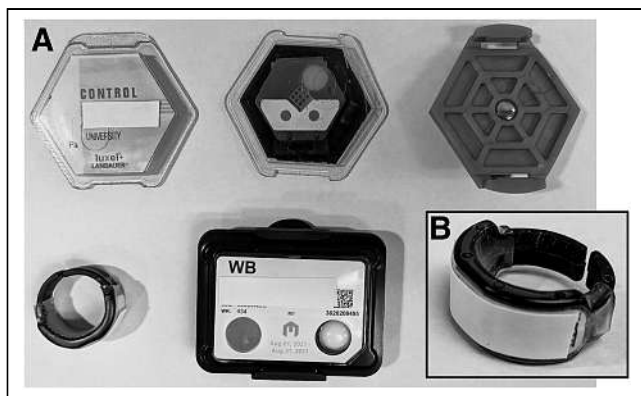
Radiation monitoring badges measure over time and do not provide real-time radiation exposure read-out. (A) Clockwise from top left: Luxel+ (Landauer) dosimeter badge that measures radiation exposure due to x-rays, γ -rays, and β -rays with optically stimulated luminescence (OSL) technology (15); inside of OSL badge; holder clip for Luxel+ OSL badge; film badge to measure and record radiation exposure due to x-rays, γ -rays, β -rays, and neutron radiation, which incorporates series of filters to determine quality of radiation; and a thermoluminescent extremity badge with a better view in B (16). (B) Thermoluminescent dosimetry extremity badge that measures exposure due to x-rays, β -radiation, and γ -radiation (17).
